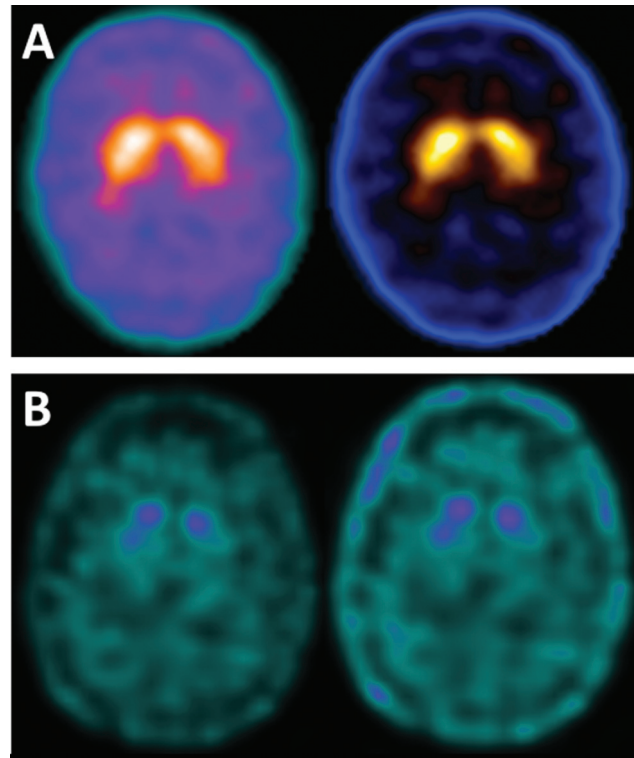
DAT SPECT with ^{99m}Tc-TRODAT-1. (A) shows a normal DAT SPECT from a healthy subject, while figure (B) discloses a marked decrease in dopamine in a patient with Parkinson's disease. This image is from the personal archive of the authors.
